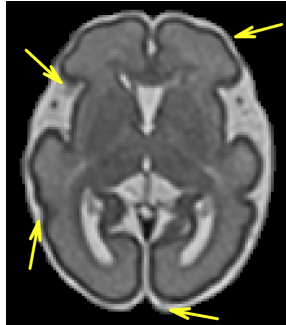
Examples of partial volume effect (arrows) in the boundaries between gray matter and cerebrospinal fluid, and background and cerebrospinal fluid in an axial MRI slice of a 29 GWs fetus.
